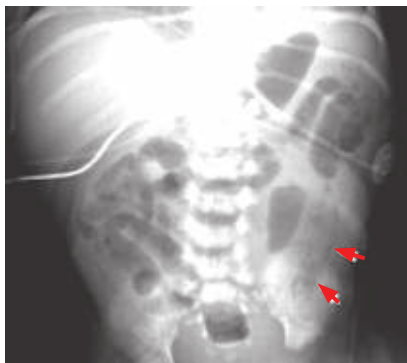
Pneumatosis intestinalis. Arrows highlight pneumatosis intestinalis on an abdominal x-ray of a patient with necrotizing enterocolitis. Intramural air bubbles shown in the image represent gas produced by bacteria within the bowel wall. (Reproduced with permission from Brunicaardi FC et al. *Schwartz's Principles of Surgery*, 9th ed. New York, NY: McGraw-Hill; 2010.)
